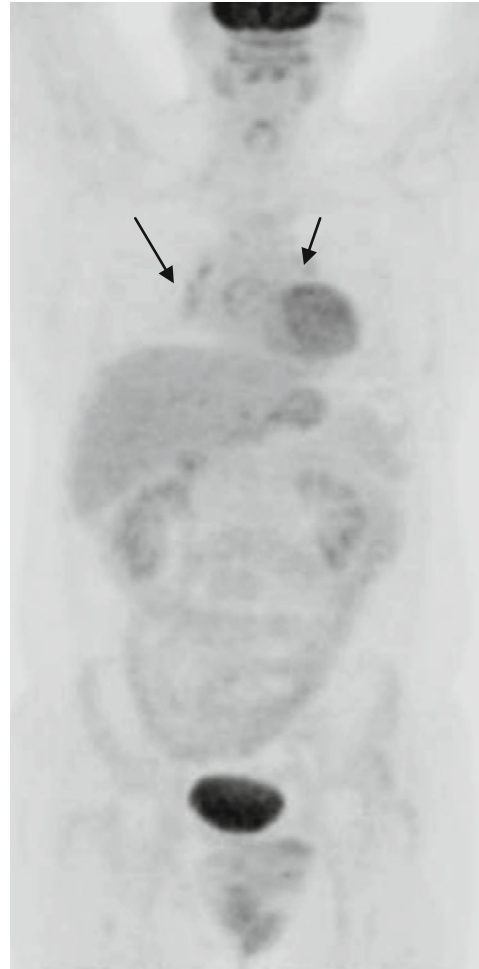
PET/CT after the end of chemotherapy. Low-grade, abnormal 18-FDG uptake (SUVmax 3) in bilateral hilar and peribronchial as well as right paratracheal and subcarinal lymph nodes (arrows). The uptake was equal to that of the liver corresponding to a D5-PS score 3
